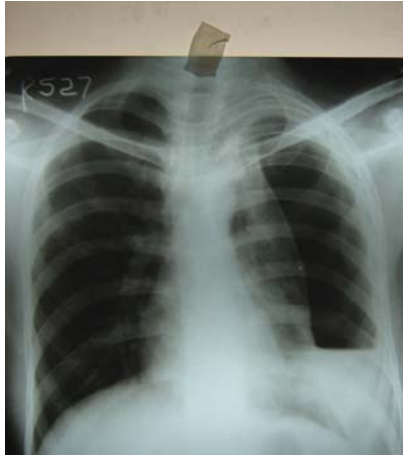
X-ray of chest showing homogenous opacity left side of chest with shifting of mediastinum to right side.
